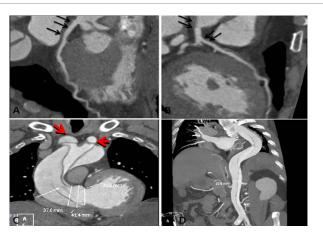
Aorta CTA: aortic dissection (Stanford type A), involving LMCA and LAD(Black arrows) and Right innominate artery(Red arrows), bilateral common carotid artery(Red arrows), bilateral subclavian artery(Red arrows), coeliac trunk artery, splenic artery, right renal artery, superior mesenteric artery.
